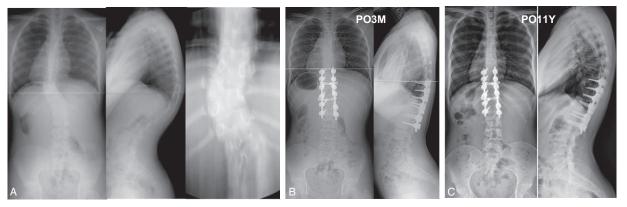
(A) A 9-year-old female who had congenital hemivertebra of T11and T12 with 40° of left thoraco-lumbar scoliosis and segmental kyphosis of 54°. (B) Postoperative 3 months radiographs showed that the main curve improved to 6° with satisfactory deformity correction. (C) Eleven years follow-up radiographs showed that the main curve maintained 7° without curve progression. The preoperative unequal coronal and sagittal balance improved after surgery and were maintained during follow-up period.
